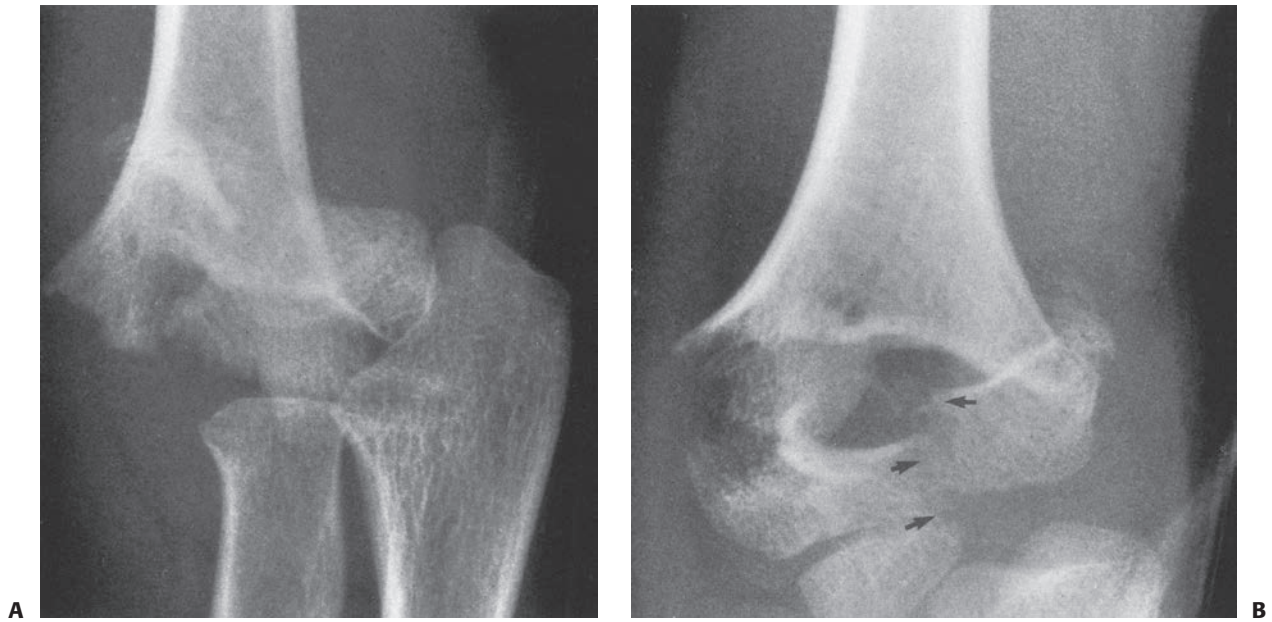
Occult T-condylar. A: Original x-rays appear to show a type III posteromedial supracondylar fracture. B: After manipulation, the vertical intercondylar fracture line (arrows) was visualized.
